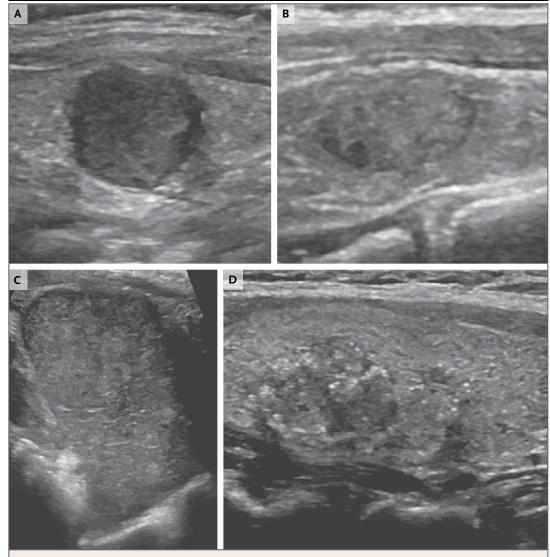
Ultrasonographic Images of Thyroid Nodules.
